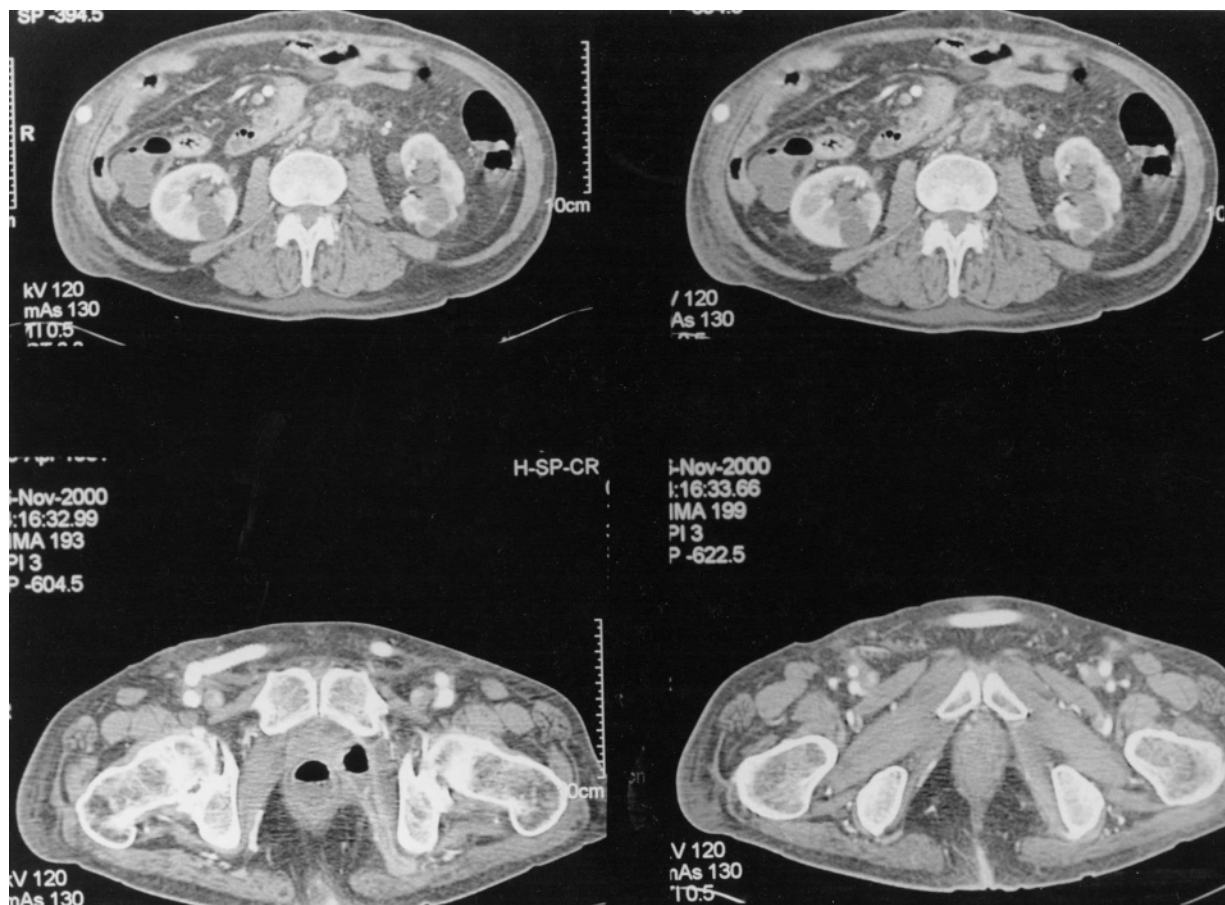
Spiral CT scan (15 days after redo surgery) shows the stump of the aorta, the absence of fluid collection and a patent axillo-bifemoral bypass.
